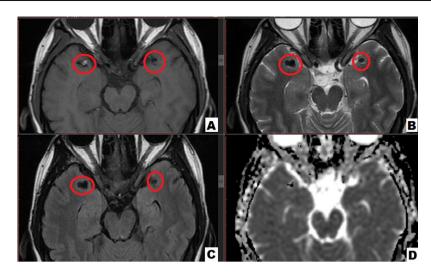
Preoperative magnetic resonance images (MRI) revealed on bilateral middle cerebral arteries' aneurysms. The red cycles indicate to the aneurysms. (A) T1-weighted MRI; (B) T2-weighted MRI; (C) T2-flair-weighted MRI; and (D) apparent diffusion coefficient (ADC). (For interpretation of the references to color in this legend, the reader is referred to the web version of the article.)
